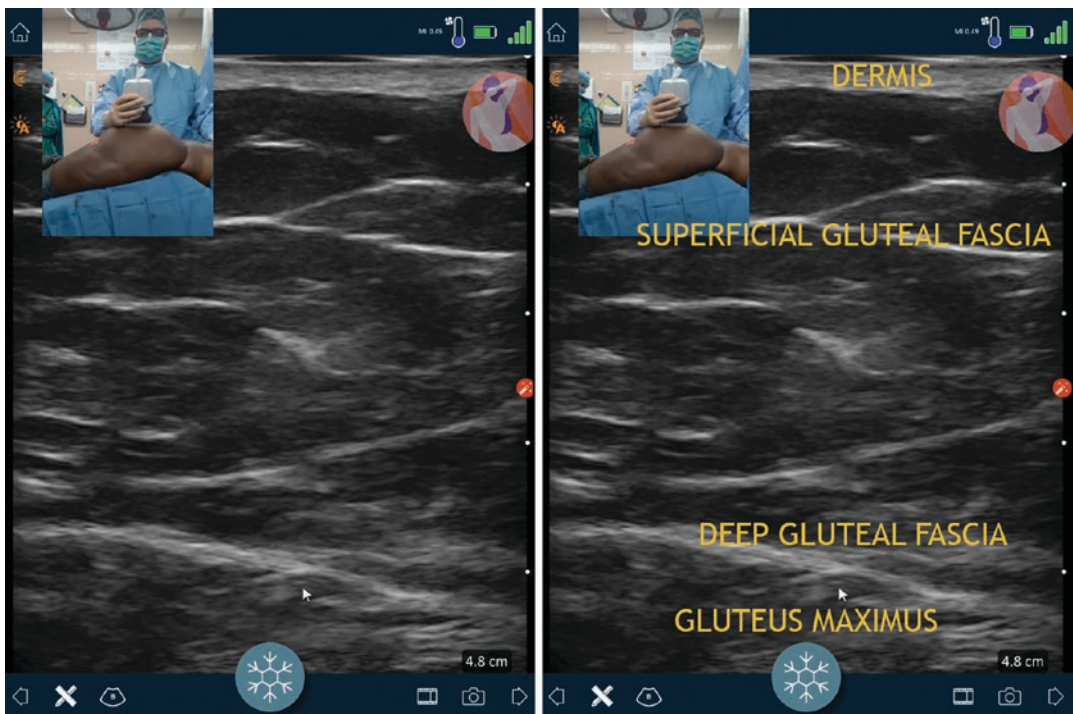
Central dome preinjection: The Clarius portable wireless ultrasound probe is placed over the central dome of the buttock. The probe is transmitting the image to the tablet that is facing the surgeon. The dermis, superficial gluteal fascia, deep gluteal fascia, and gluteus maximus are noted. The superior surface of the gluteus maximus is covered with the deep gluteal fascia and is 4 cm below the skin
